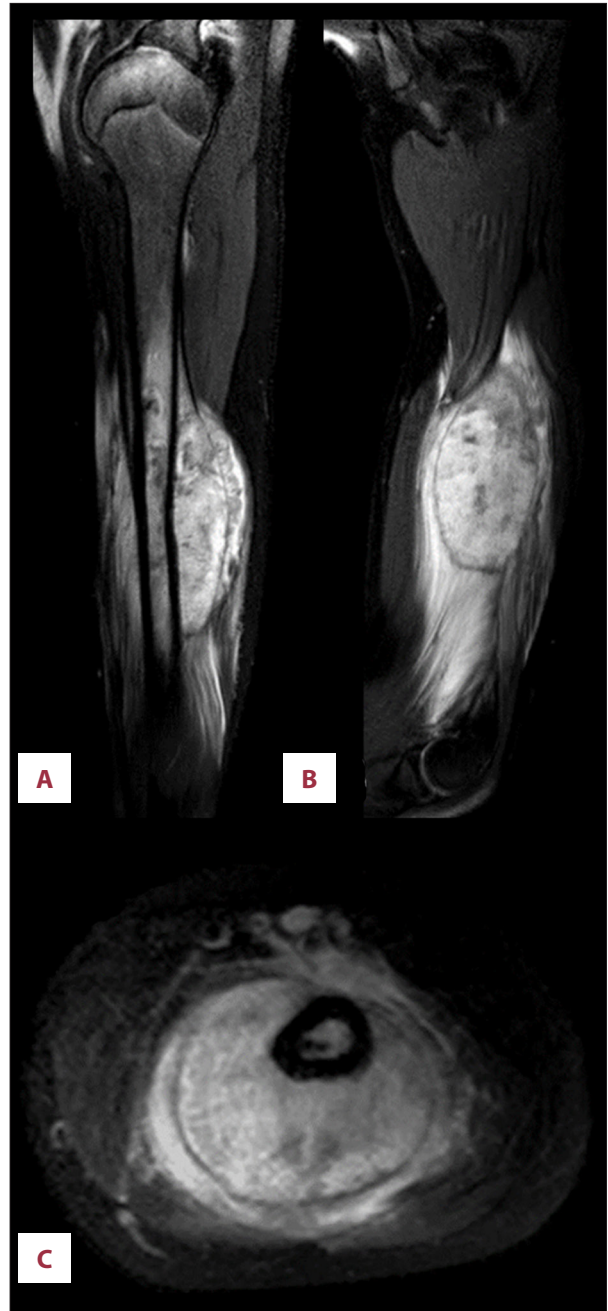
T2-weighted magnetic resonance images in the (A) sagittal, (B) coronal, and (C) axial planes of the left humerus, demonstrating a heterogenous soft tissue mass arising from and encasing the entire circumference of the midshaft of the humerus. Irregular periosteal reaction is noted at the periphery of the mass.
